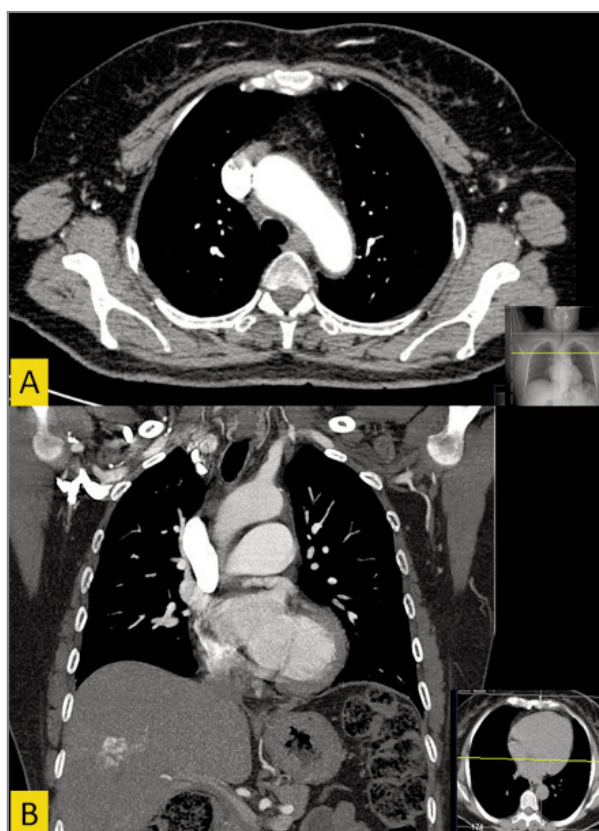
Contrast-enhanced computed tomography showing complete resolution of the aortitis signs. (A – axial and B – coronal reconstruction planes).
